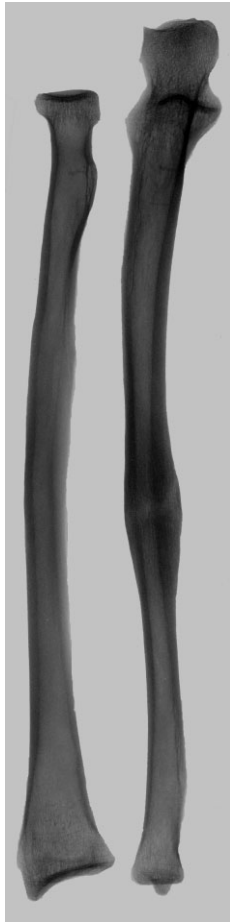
Anterior-posterior radiograph of Motmot individual's right forearm.
